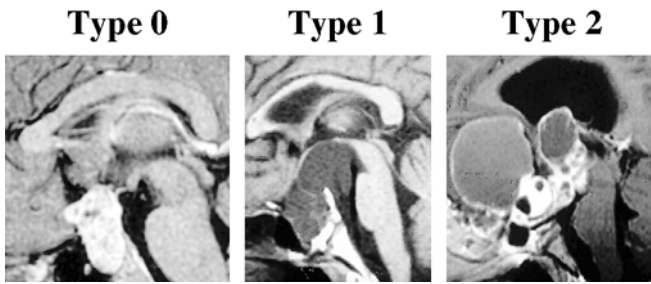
MRI assessment of hypothalamic involvement. *Type 0*: no involvement of the hypothalamus; *type 1*: the hypothalamus is elevated/distorted but visible, *type 2*: the hypothalamus is involved and no longer visible
